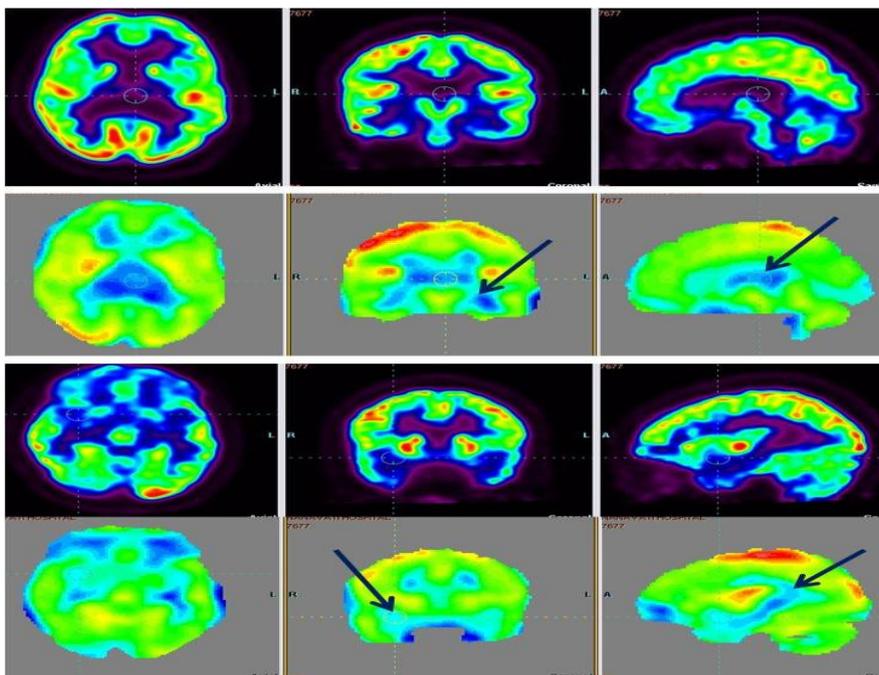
18FDG PET in 16 years old boy with autism shows reduced FDG uptake (blue arrows) in mesial temporal structures like amygdala and hippocampus.
